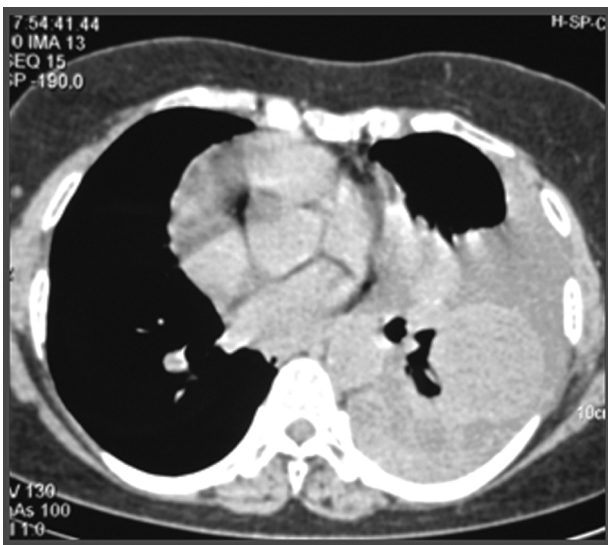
Computed tomography of the chest showing left pleural effusion with an underlying lung mass.
